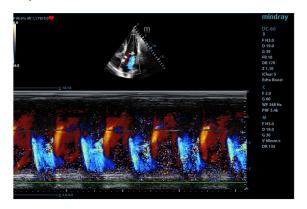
Mitral regurgitation due to sustained ischemia (color M-mode, apical 4-chambers view) in a case with LV posterolateral myocardial infarction
